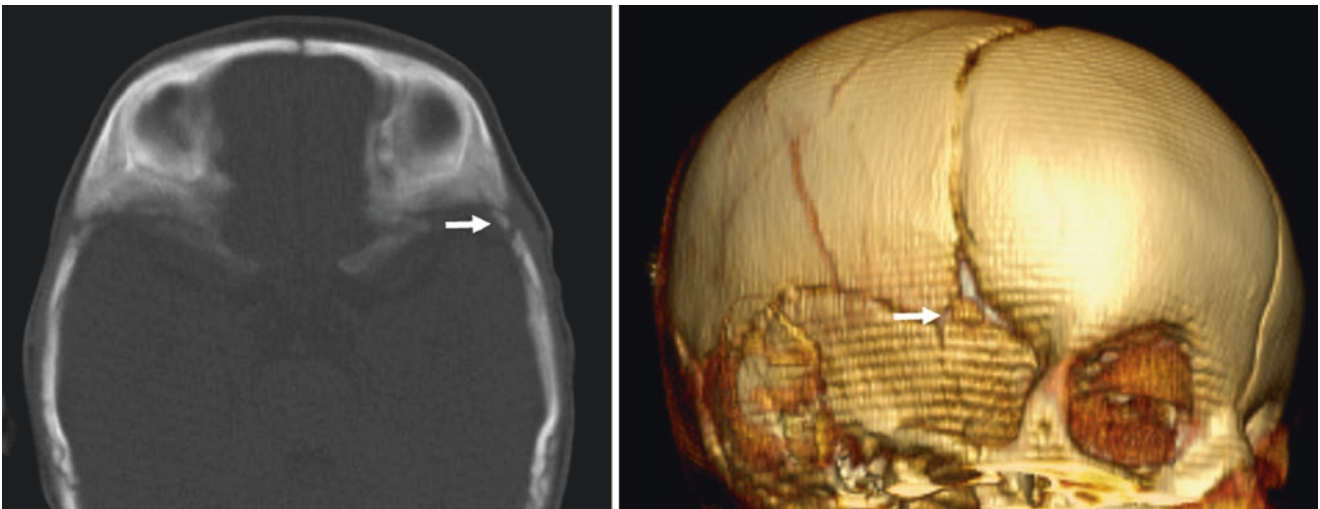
In a 3 month old an intrafonticular sutural bone within the sphenoid fontanelle (*arrows*) is shown on axial 5-mm MPR (*left*) and on a 3D VR CT right lateral view (*right*)
